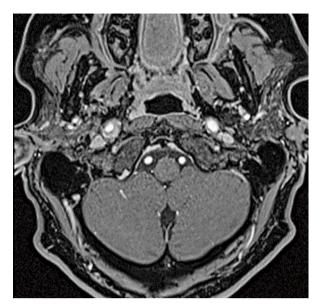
Right carotid artery dissection on MRI
